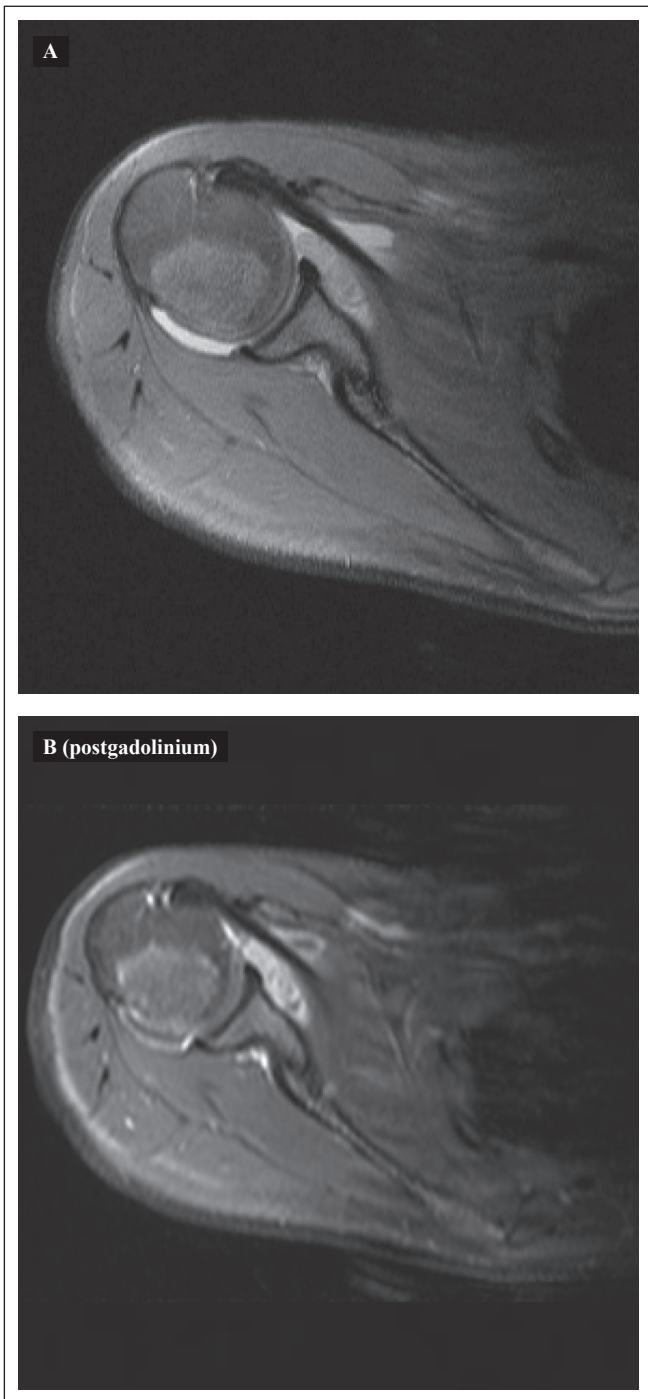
MRI of right shoulder demonstrate discrete diffuse synovial thickening, hypercaptant by contrast, with moderated effusion in the glenohumeral articular space. Presence of soft tissues mass, of oval aspect, compromising the subscapular bursa and the axillar recess regions. Images in T2-weighted sequences with fat saturation with low intensity signal, with small granules in between. Signal indicative of glenohumeral synovitis with joint effusion. Expansive content of soft tissues in the subscapular bursa and in the axillar recess, which could correspond to tissual hypertrophy of the synovia (pannus).
